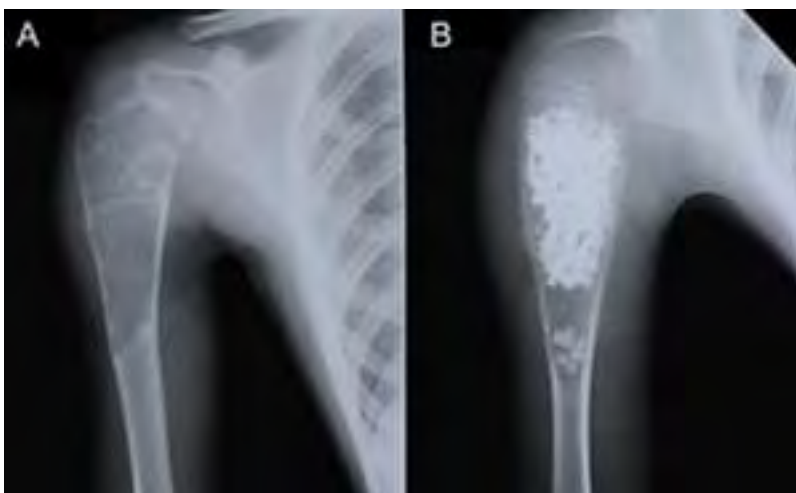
A) An X-ray shows an expansile lytic lesion in the right proximal humerus consistent with a simple bone cyst. B) A post-operative x-ray after curettage and grafting with synthetic bone substitute. (<https://www.sciencedirect.com/science/article/pii/S1726490118300911>)
